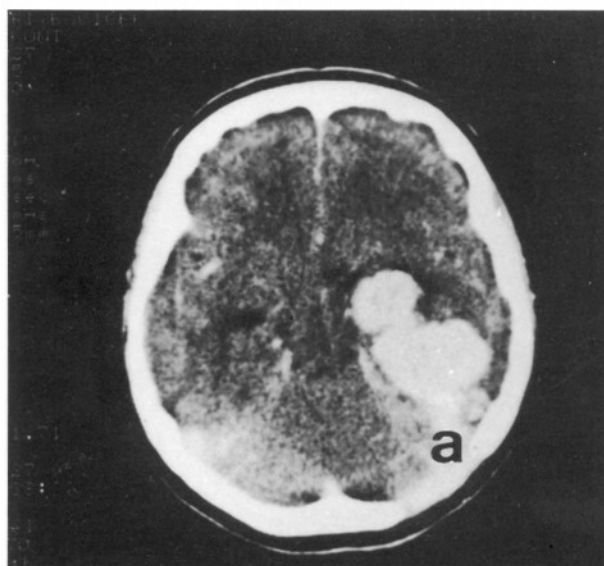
a) Preoperative CT scan of Case 1 showing a left tentorial, lobulated, hyperdense mass after contrast injection, b) after total excision of the tumor.
